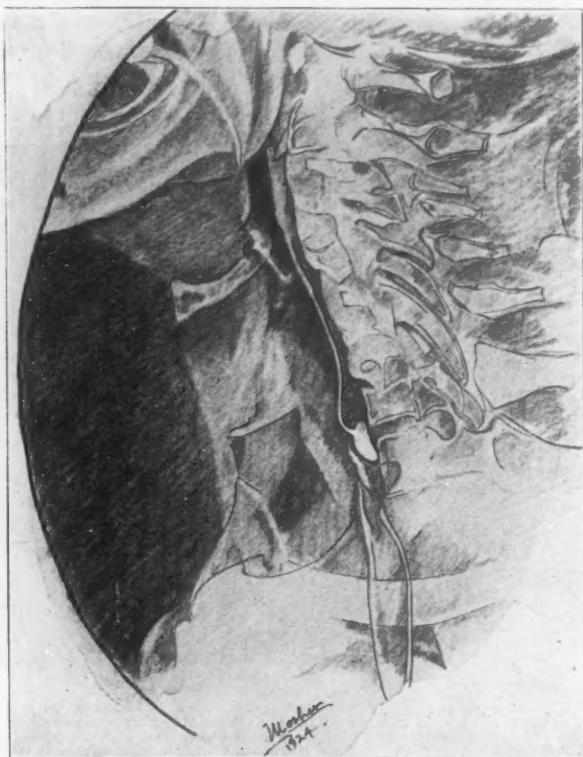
Retouched X-ray tracing. This film is the lateral view of the small pouch shown in Fig. No. 25. The upper limit of the pouch is at the bottom of the body of the seventh cervical vertebra. The opening of the esophagus is at the top of the pouch. Notice how the esophagus widens as soon as it escapes from between the pouch behind and the cricoid cartilage in front. This post-cricoid narrowing of the esophagus is characteristic of pouch cases. Notice the laxity of the pharyngeal wall just above the pouch. Reduced one-half.
